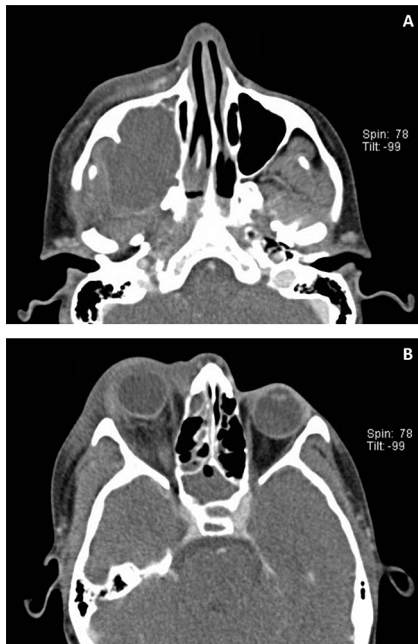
(A) CT scan demonstrating a large right maxillary cystic mass with erosion of the posterior maxillary sinus wall extending into the right infratemporal fossa. (B) CT scan demonstrating right orbital cellulitis and partial opacification of the right ethmoid and sphenoid sinuses. Right posterior globe tenting is present, signifying an acute increase in intraorbital pressure with stretching of the optic nerve.
